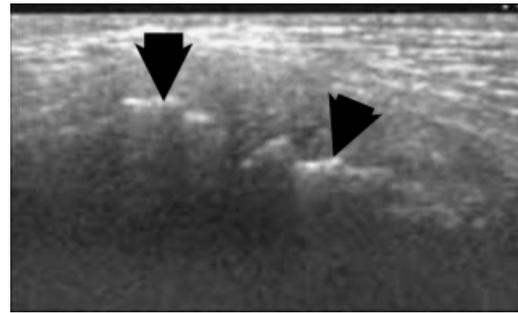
Ultrasound image of the medial aspect of the elbow joint showing irregular periarticular margins consistent with osteophyte formation (arrows).
